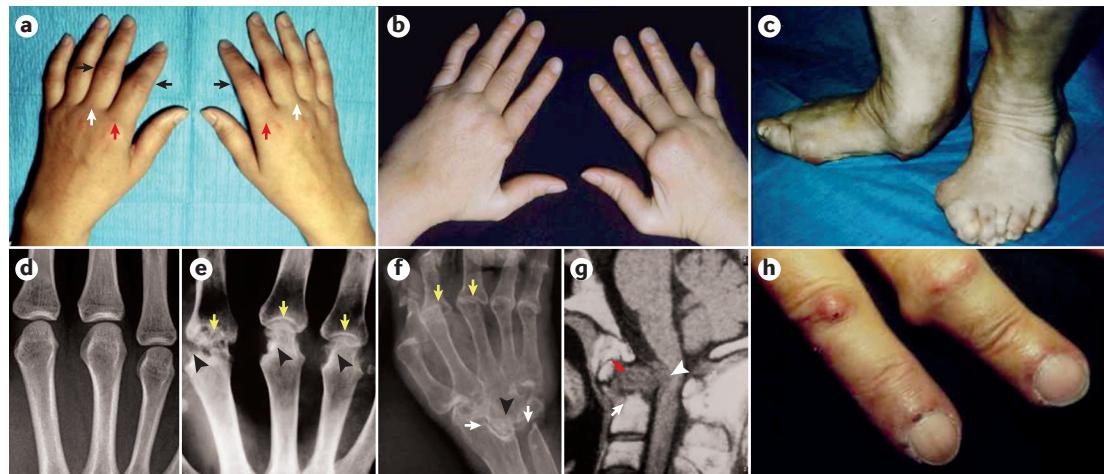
Clinical manifestations of RA. Early rheumatoid arthritis (RA; part a), characterized by mild, hardly discernible swelling of the second (red arrow) and third (white arrow) metacarpophalangeal joints on both hands and several proximal interphalangeal joints (black arrows). Established RA (part b) with various deformities, including subluxation (that is, a partial or incomplete dislocation of the joint) at the metacarpophalangeal joints, swan-neck deformities of several fingers, most prominently seen at the fifth digit (the little finger), and a Z deformity of the thumb in the right hand. Late, severe RA (part c) with mutilating involvement of the ankle and foot joints. Hand radiographs ranging from normal (part d) to severe damage (parts e and f) with bone erosions (black arrow head, part e) and joint space narrowing that corresponds to loss of cartilage (yellow arrows, part e) and mutilating changes, where, for example, the joint space (cartilage) between the various small carpal bones is used up and they coalesce to almost form a type of a 'single' bone (that is, "os carpale"; black arrowhead, part f). Mutilating changes also involve pencil-in-cup deformities (yellow arrows, part f, point to the 'cup') and destruction of the distal radius and distal ulna where they interact with the carpus (white arrows, part f). MRI of the cervical spine (part g) shows severe pannus formation (red arrow) at the atlantodental joint with compression of the medulla (white arrowhead) due to synovial hyperplasia. The dens of the axis shows severe erosions (white arrow). Presence of rheumatoid nodules (part h) on the dorsal and lateral sides of several fingers and periungual vasculitis at the nailfolds (black dots). Parts d and e are adapted from REF. 248, Macmillan Publishers Limited.
